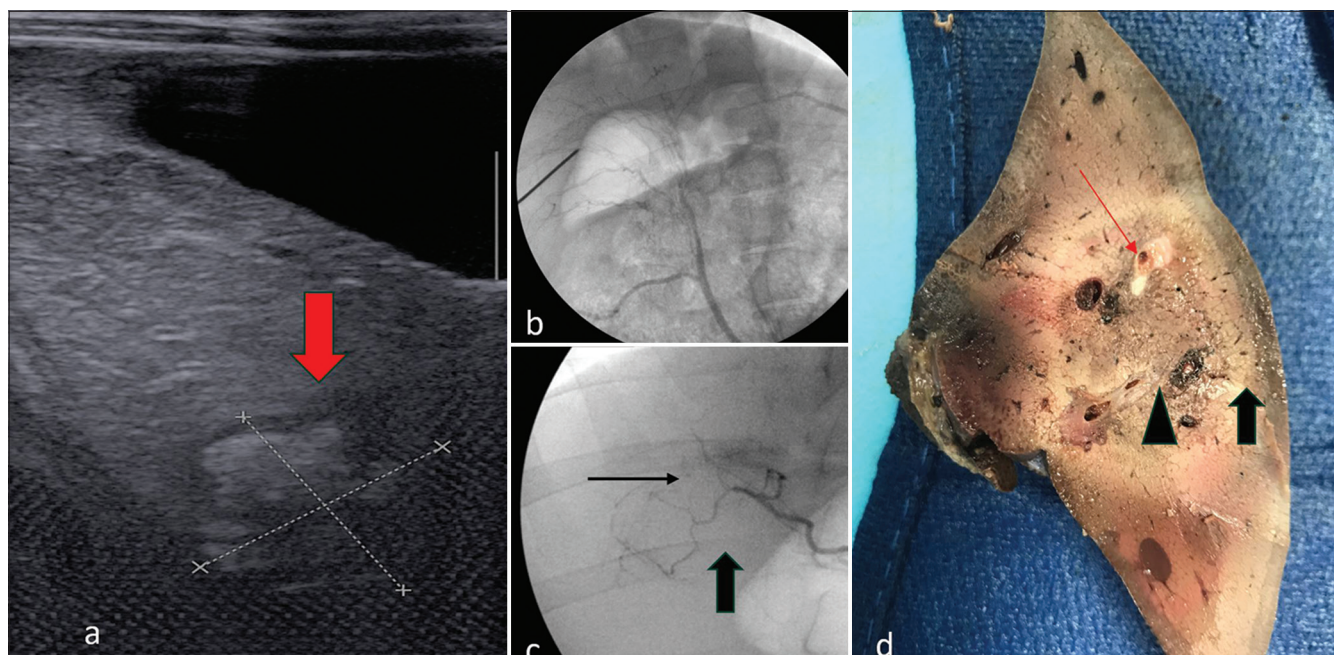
Liver tumor ablation in transgenic oncopig after embolization. (a) Ultrasound of the liver tumor (red arrow) Tumor is measured with calipers on Ultrasound Image. (b) Angiography of liver segment containing the liver tumor before embolization. (c) Post-embolization angiography with thin black arrowing showing tumor blush and thick black arrow identifying stasis of vascular flow within the tumor. (d) *Ex vivo* evaluation of the ablation zone after embolization. Black arrow is the non-charted coagulative zone, black triangle is the charred central portion, and the red arrow is the ablated tumor.
